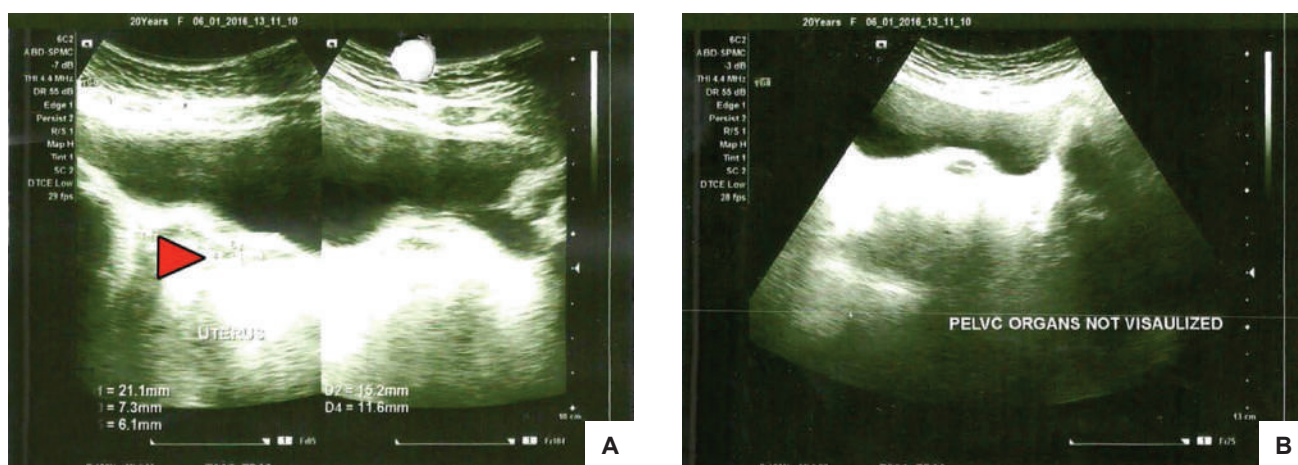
Transrectal ultrasound revealed (A) infantile uterus (red arrow) and (B) non-visualized ovaries.
